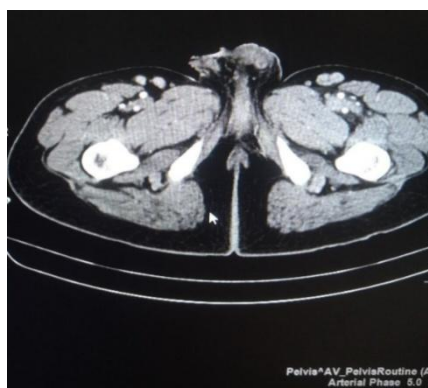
3 CT Scan Pelvis axial cross section of testis
